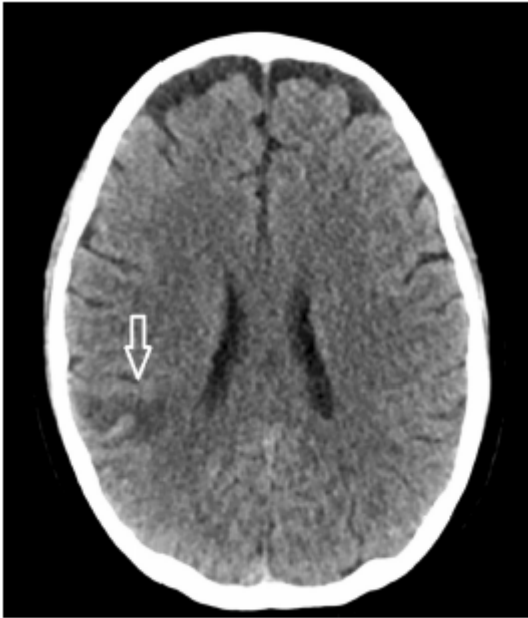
Computed tomography image, axial slice through the lateral ventricles. The arrow shows a small, hyperdense hemorrhage, juxtacortical in the right parietal lobe. Perilesional edema is visible as a surrounding hypodense rim
